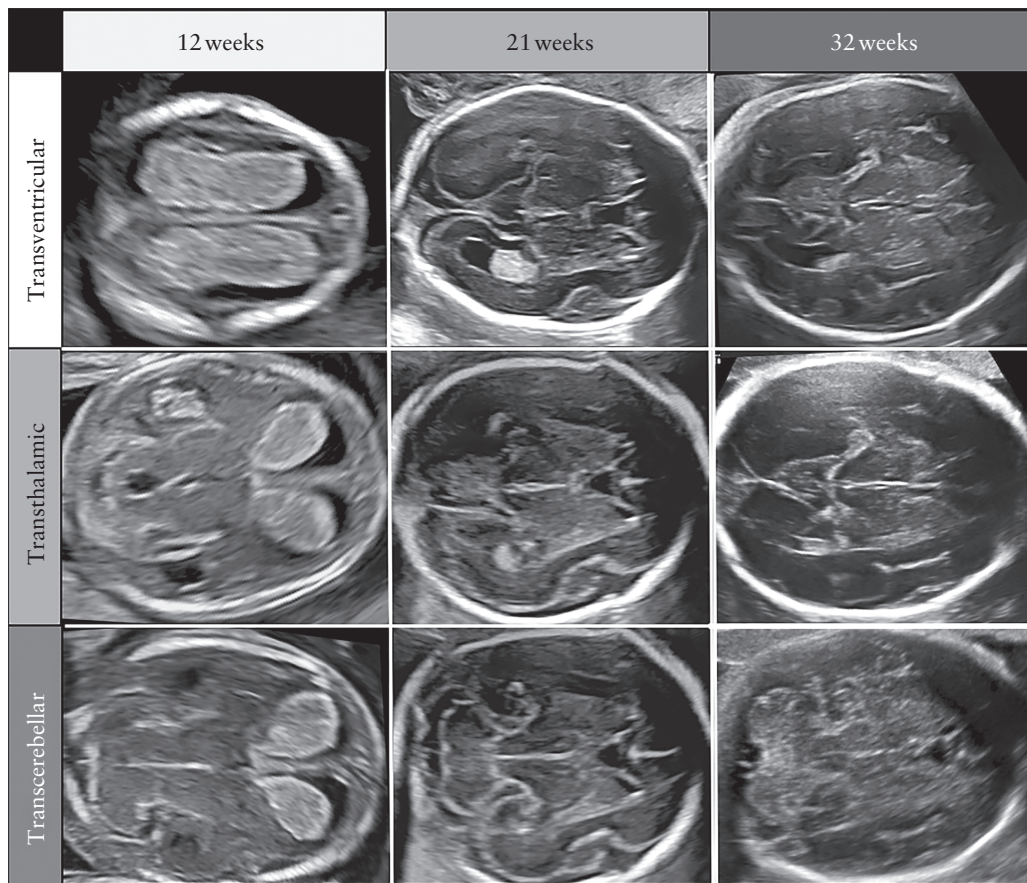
Normal morphological changes of fetal brain throughout gestation, as visualized on sonographic examination in axial planes: views in transventricular, transthalamic and transcerebellar planes at 12, 21 and 32 gestational weeks. Note significant structural change of lateral ventricles and choroid plexus from late first trimester to midgestation, along with appearance of cavum septi pellucidi only from early second trimester onwards. Nevertheless, ventricular atrial width remains relatively stable during second and third trimesters.
